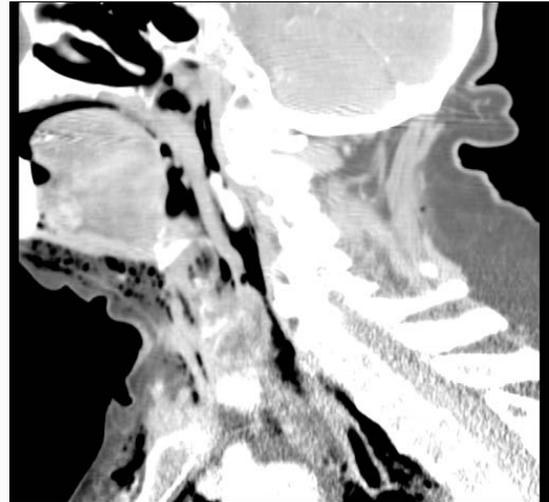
Sagittal CT scan of the neck after 10 days later the operation. Complete regression of the two abscesses.
